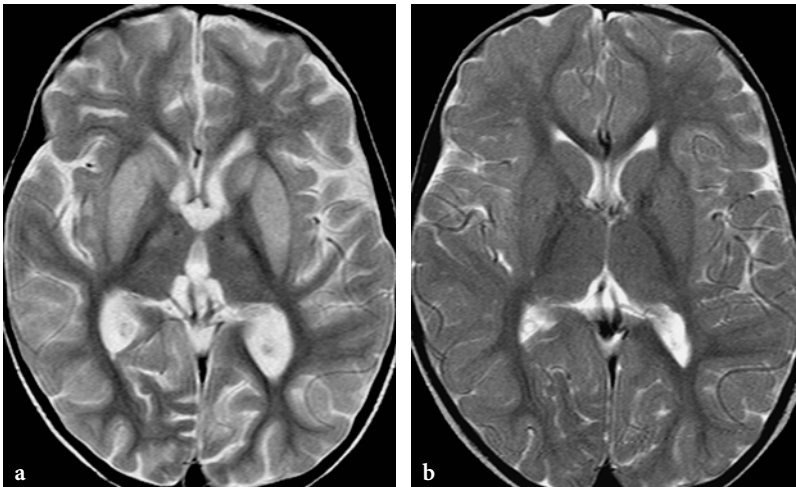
Total resolution of basal ganglia lesions on the follow-up study. Axial T2-weighted spin-echo images in a female patient with propionic acidemia. a Prominent basal ganglia signal abnormalities at the age of 3 years, immediately after a metabolic crisis. b The follow-up study 1 year later shows practically total disappearance of the basal ganglia changes
